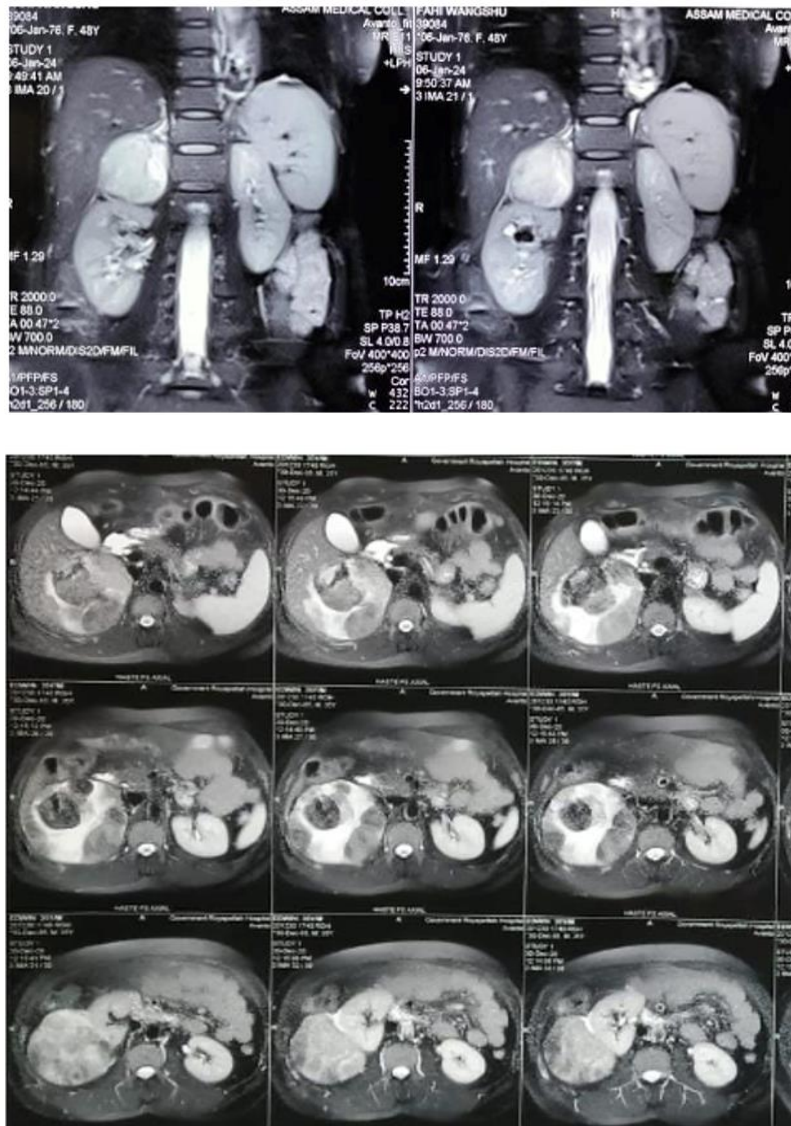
MRI showing adrenal mass
